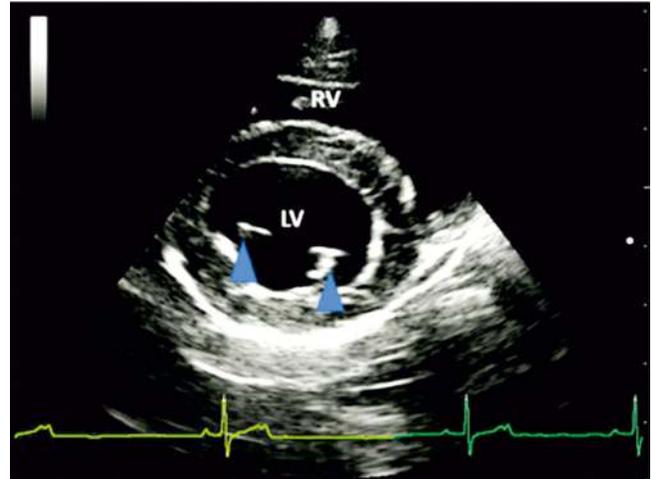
Parasternal short axis view at the cordae tendinae level. The left ventricle chamber is more rounded compared the previous section and chordae tendinae appear as a hyperechoic structure (the blue arrow heads-cordae tendinae)
